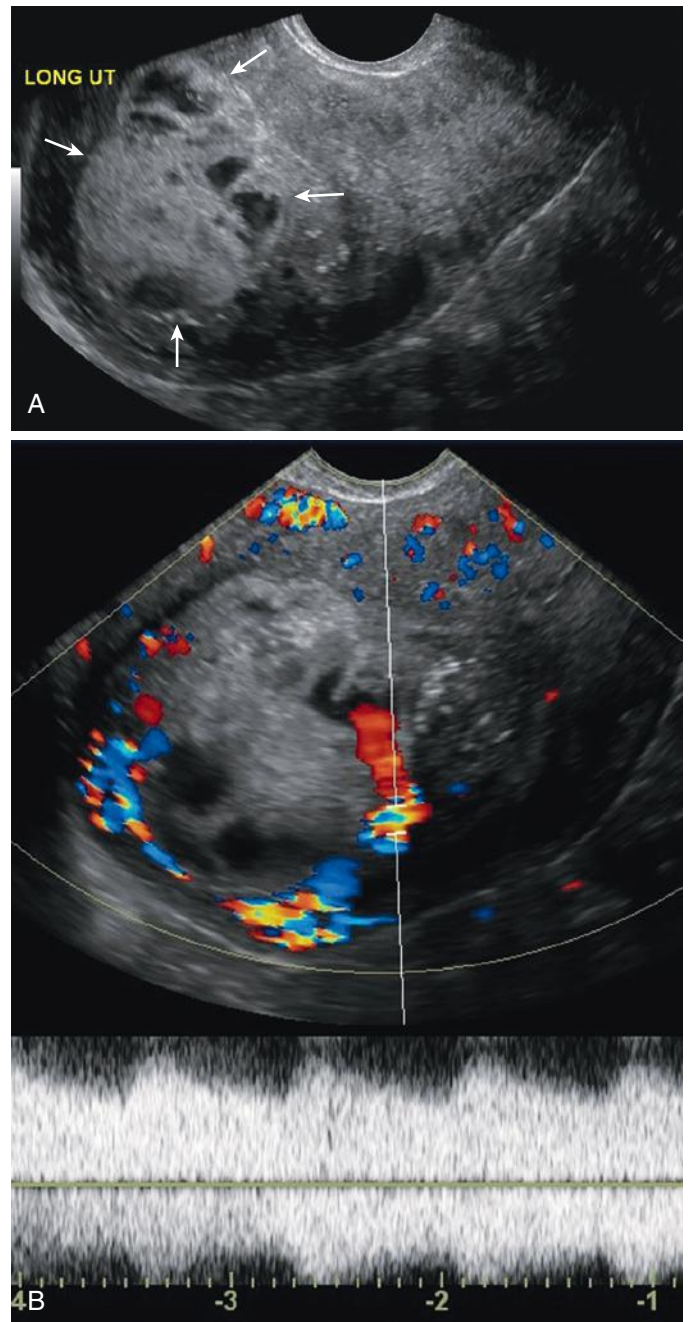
Transvaginal sagittal sonogram from a patient presenting with continuous vaginal bleeding 2 months after delivery. A, A complex predominantly hyperechoic solid mass (*arrows*) was seen within the uterine fundus. B, Doppler evaluation demonstrates high-velocity low-resistance flow. This was retained placental tissue.
